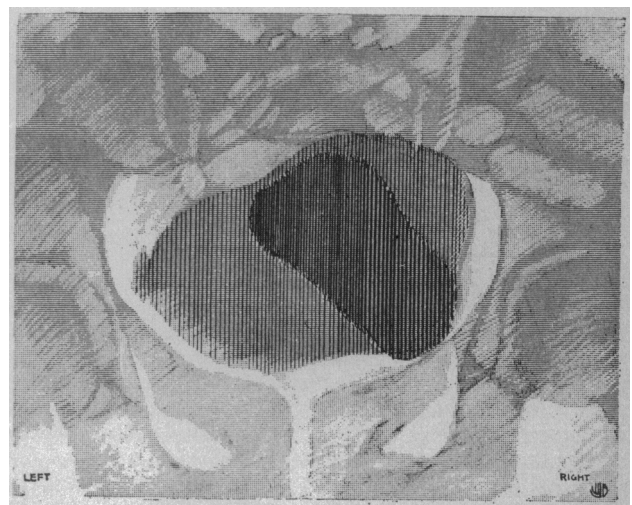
Large diverticulum in the posterior part of the bladder (Case 6) as shown by Roentgen ray.
